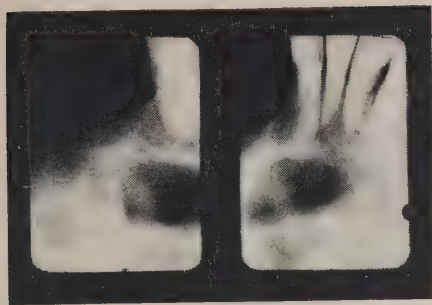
Roentgenogram taken February 7, 1949.
